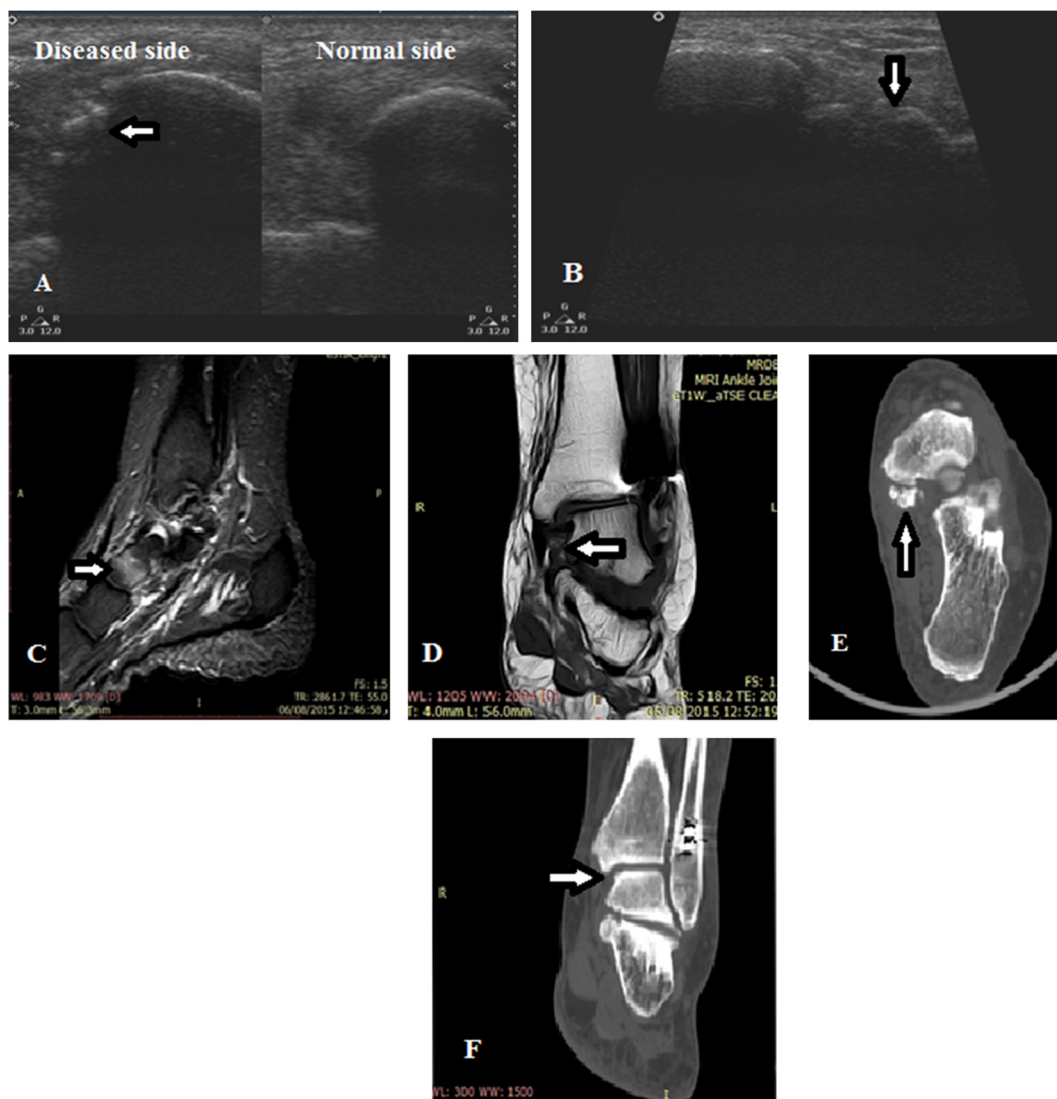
A. Transverse US image showing osteoarthritic changes where the diseased ankle joint shows superimposed bone (white arrow) with irregular bony surface appearance while the contralateral side shows normal healthy ankle joint. B. Longitudinal US image shows osteophyte lipping going with osteoarthritic changes (white arrow). C. Sagittal STIR image shows navicular bone marrow oedema (arrow). D. Coronal T2WI shows intact deltoid ligament with normal signal of its fibers (white arrow). Fig. E. Axial CT image bone window shows multiple bony fragments noted at medial aspect of navicular bone the largest around 10 mm (white arrow). F. Coronal CT image bone window Osteoarthritic changes are noted by osteophyte lipping (white arrow).
